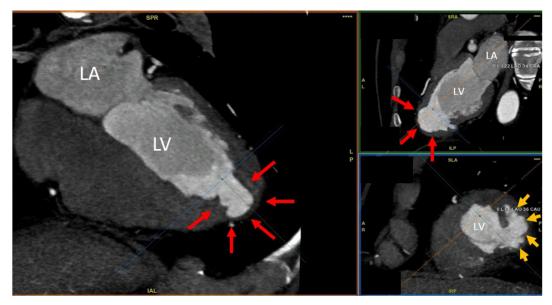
Cardiac computed tomography multiplanar reconstruction images in representative apical 4-chamber (*left*), apical 2-chamber (*top right*), and apical short-axis (*bottom right*) views depicting the aneurysmal outpouching at the apex (*red arrows*) and anterolateral (*yellow arrows*) myocardial wall segments with a relatively wide neck and smooth transition from the adjacent normal myocardium to the thinned aneurysmal wall. *LA*, Left atrium; *LV*, left ventricle.
